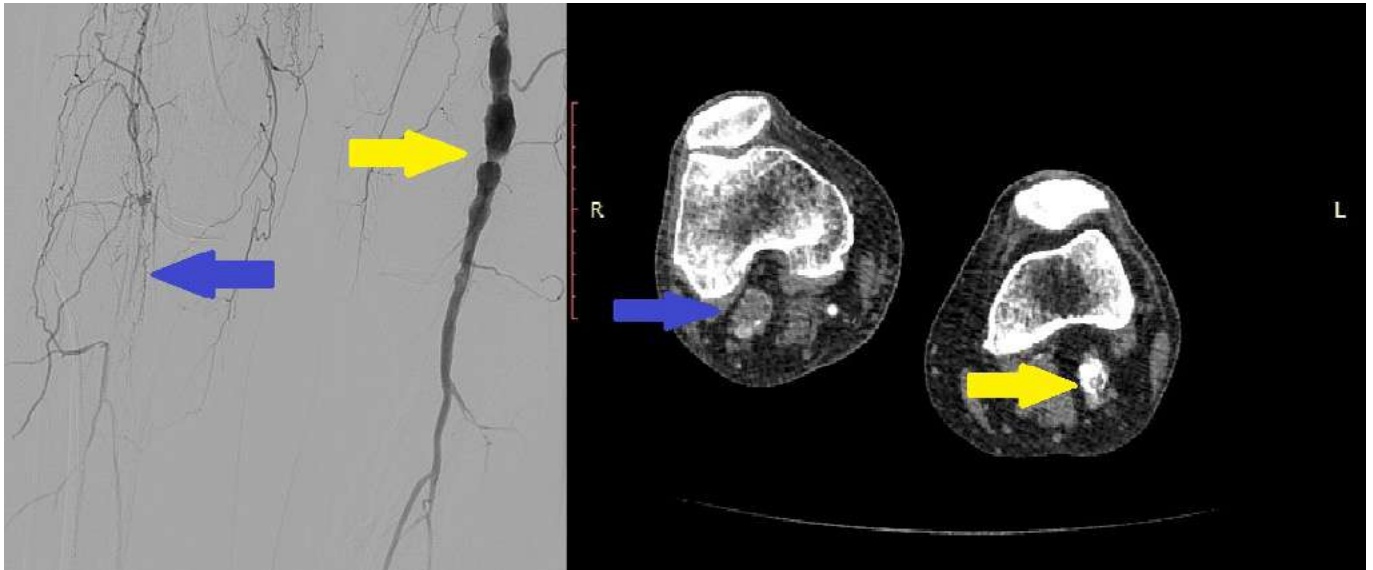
Emergent DSA (left) and complimentary CTA (right) showing bilateral PA aneurysms - the left thrombosed (blue arrow) and the right still patent (pink arrow).
